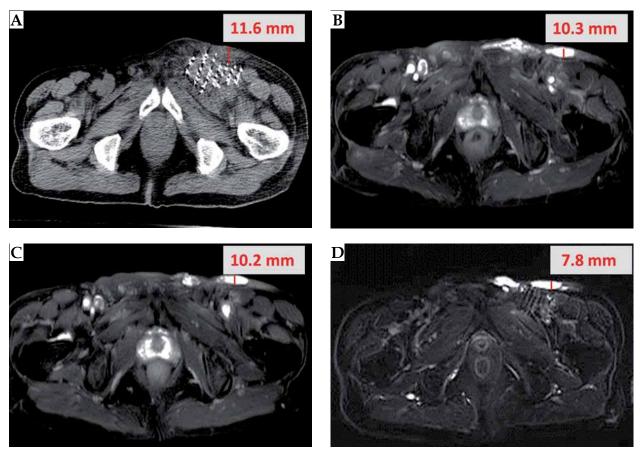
Images of hyaluronic acid (HA) for Patient 7. A) Point of injection on CT; B) 1 month after the injection on MRI; C) 2 months after the injection on MRI; D) 3 months after the injection on MRI
